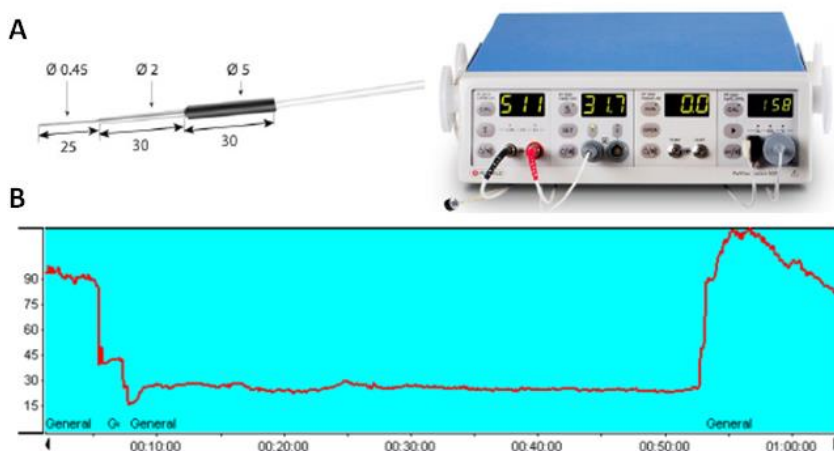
Doppler registration during occlusion of the middle cerebral artery. (A) Doppler probe. (B) Graphical representation of the doppler register. It represents the drop of blood flow during the occlusion of the tMCA and its subsequent rise during reperfusion. Self-created figure.
